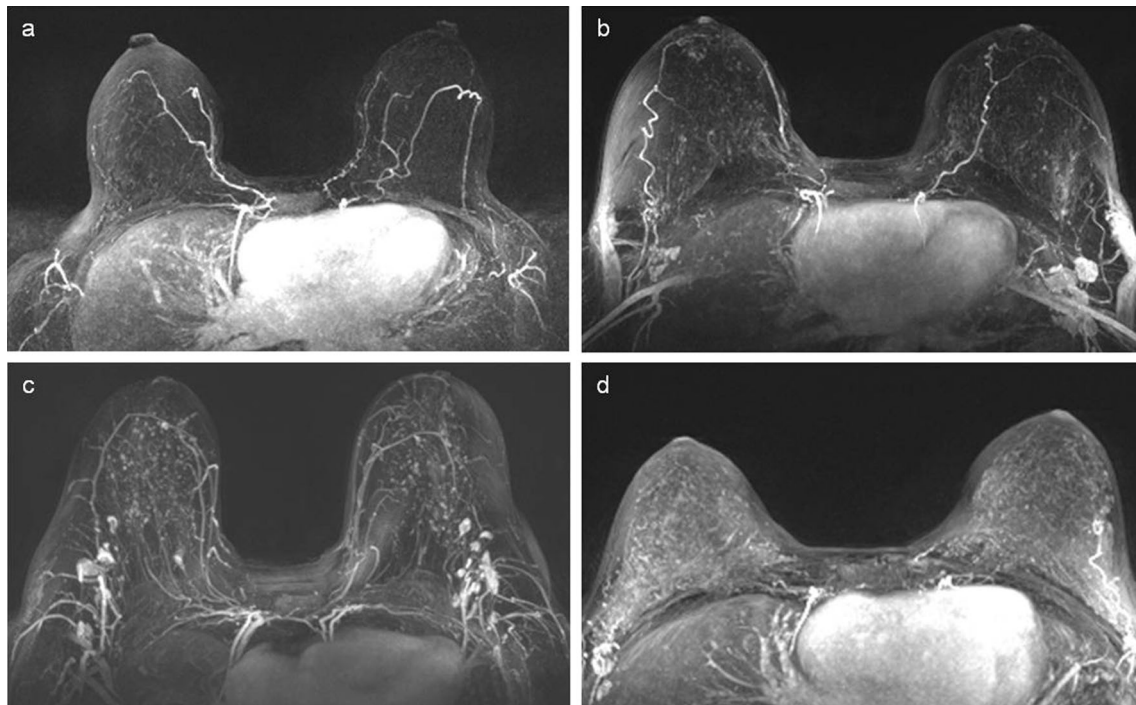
a Minimal, b mild, c moderate, and d marked BPE on axial contrast-enhanced T1-weighted fat-suppressed subtraction MIP MR images
